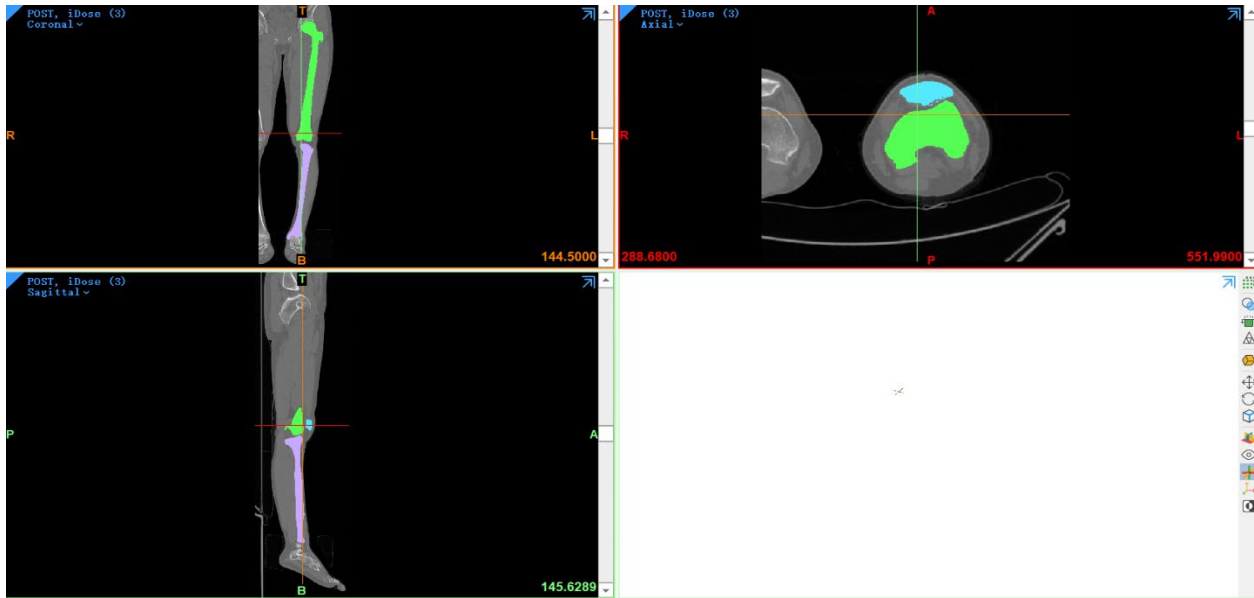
CT and MRI image (a): CT image in Mimics software (b): MR image in Mimics software
